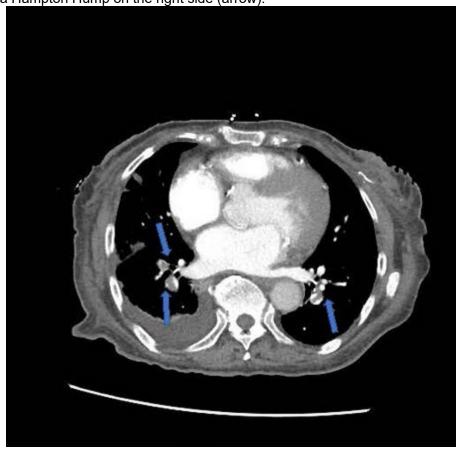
Computed tomography pulmonary angiogram confirms PE with clot burden at the bifurcation of the descending pulmonary arteries bilaterally (arrows). A left sided pleural effusion and bilateral airspace opacities are also noted.
